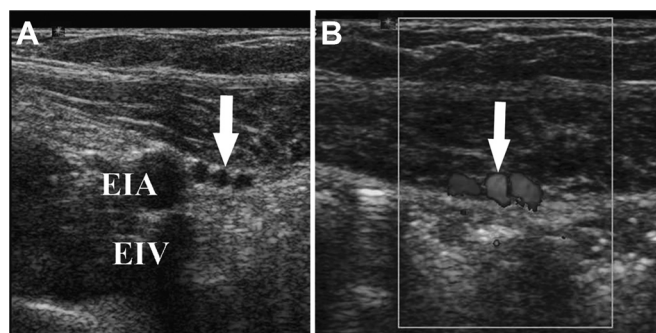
Conventional ultrasound (A) and color Duplex ultrasound (B) of the anterior abdominal wall vasculature, with the deep inferior epigastric vessels (arrows in A and B) demonstrated immediately adjacent to the pedicle origin on the external iliac artery (EIA) and vein (EIV).
